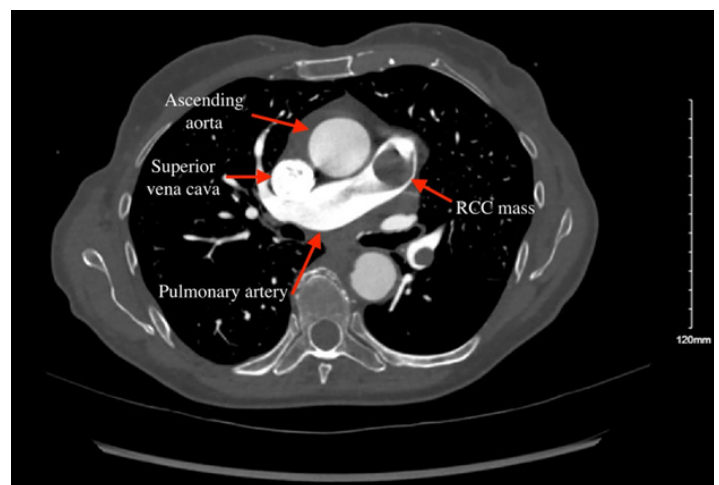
Computed tomography scan of chest in axial view of mass suspected to be renal cell carcinoma (RCC) extending into the pulmonary arteries.
